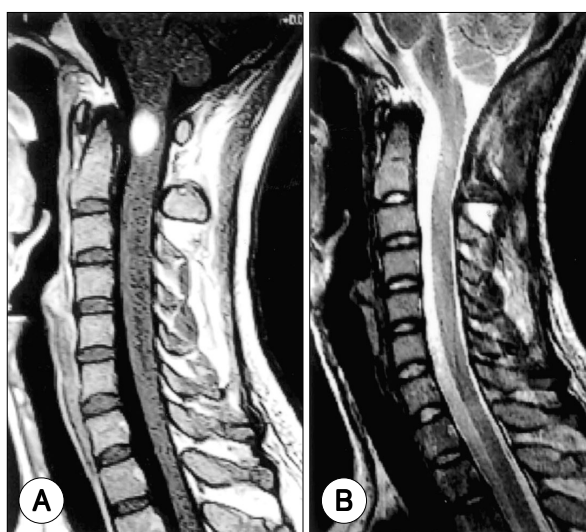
Magnetic resonance images in a ganglioglioma.
